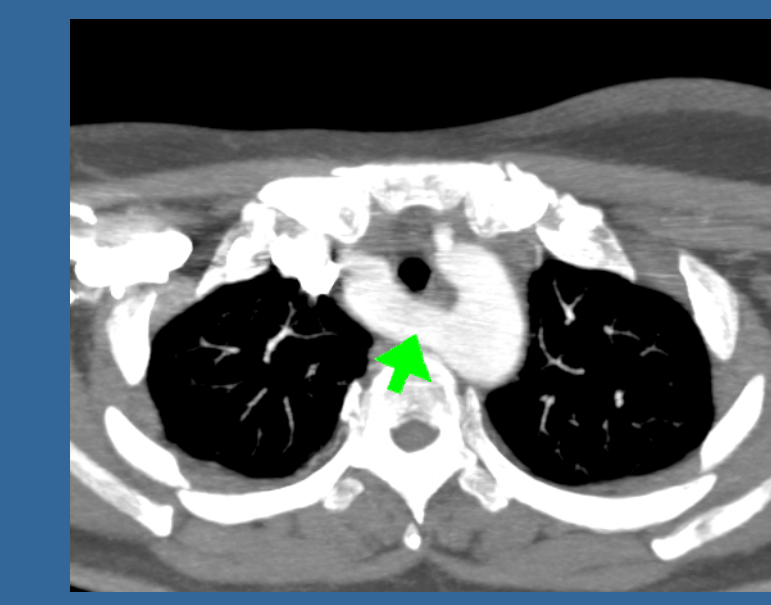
Double aortic arch(arrow) on CT angiography
